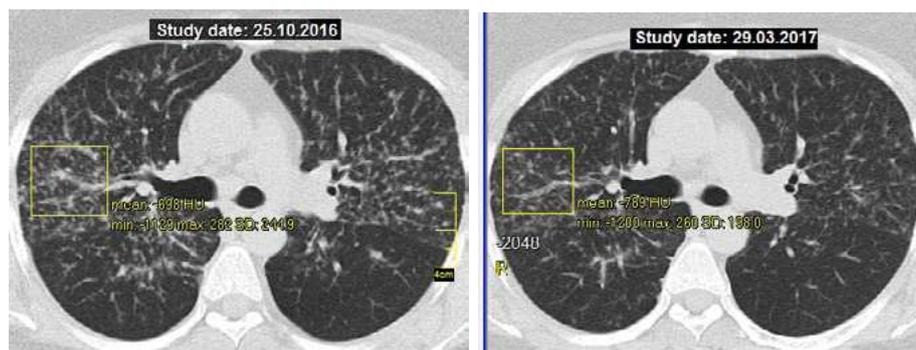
CT of patient K., sarcoidosis of lungs, II stage: *a* – before leflunomide administration, parenchyma densitometry before treatment – (–698 HU); *b* – in 3 months of leflunomide treatment: a decrease in the density of nodular dissemination of the lungs (densitometry after 3 months of therapy – (–789 HU))
